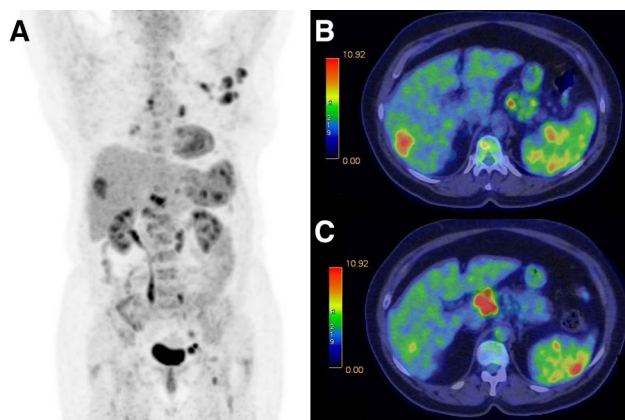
FDG-PET imaging in a 70-year-old male patient with diagnosis of Non-Hodgkin Lymphoma. a Maximal intensity projection (MIP) image shows extensive sites of involvement visualized as areas of increased FDG uptake. b, c Fused PET-CT images show sites of liver involvement (S7), peripancreatic pathological nodes, and splenic uptake of FDG
